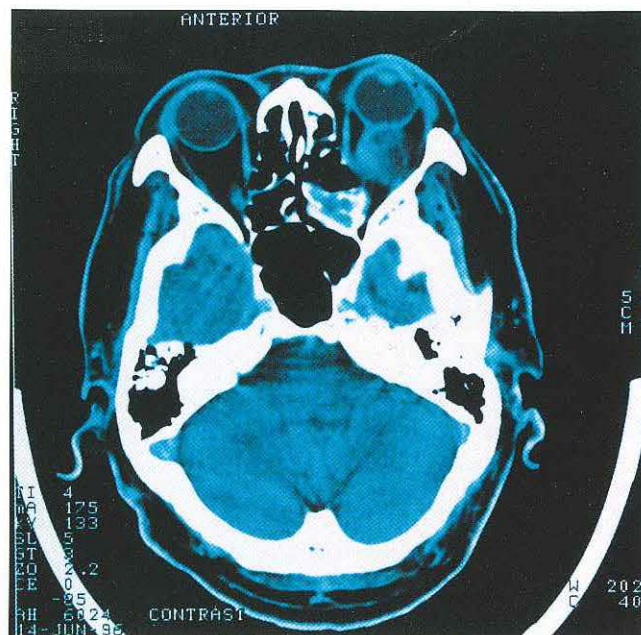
Computed tomogram of the orbits demonstrating a left well-defined intraconal mass.
